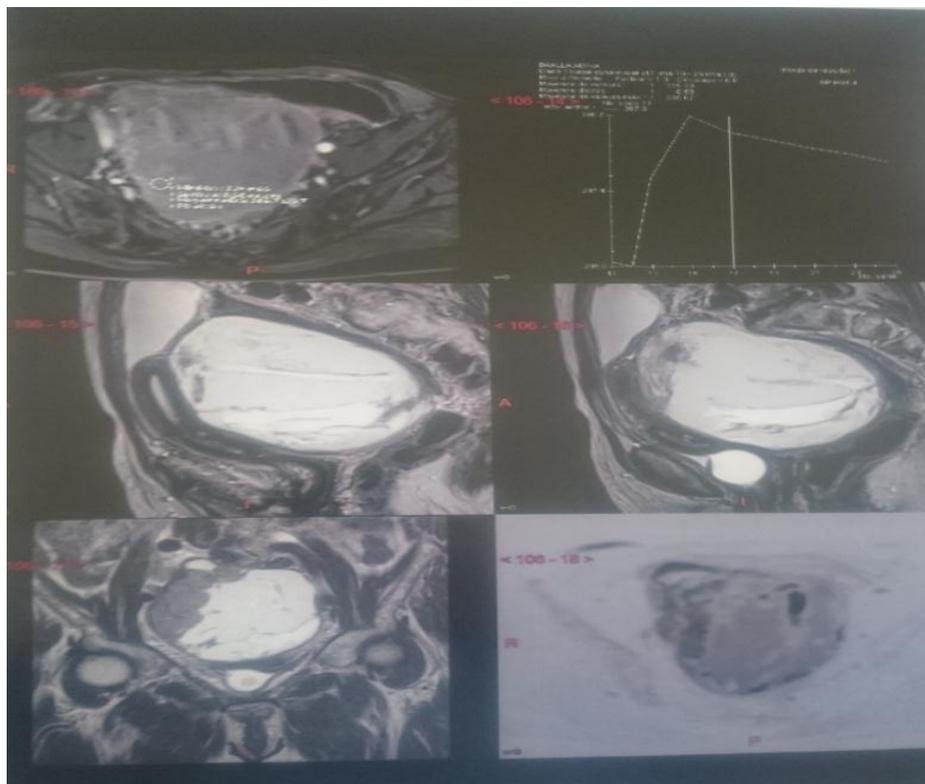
MRI findings mixed right solidocystic pelvic tumor, which the aspect was malignant.
